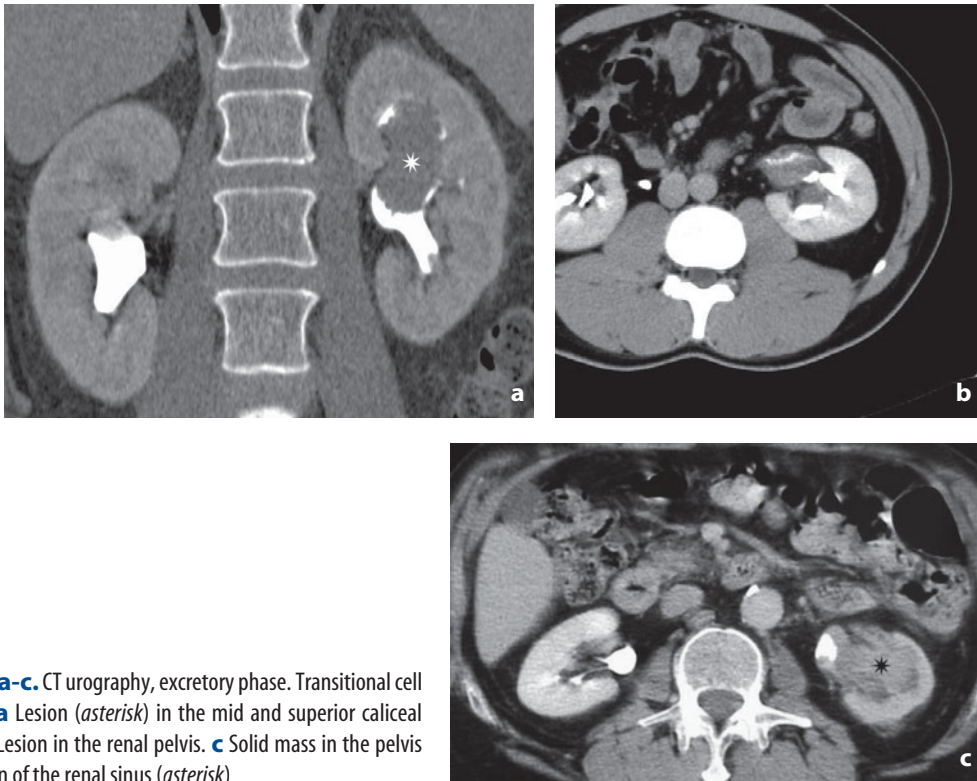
CT urography, excretory phase. Transitional cell carcinoma. a Lesion (*asterisk*) in the mid and superior caliceal systems. b Lesion in the renal pelvis. c Solid mass in the pelvis with invasion of the renal sinus (*asterisk*)
